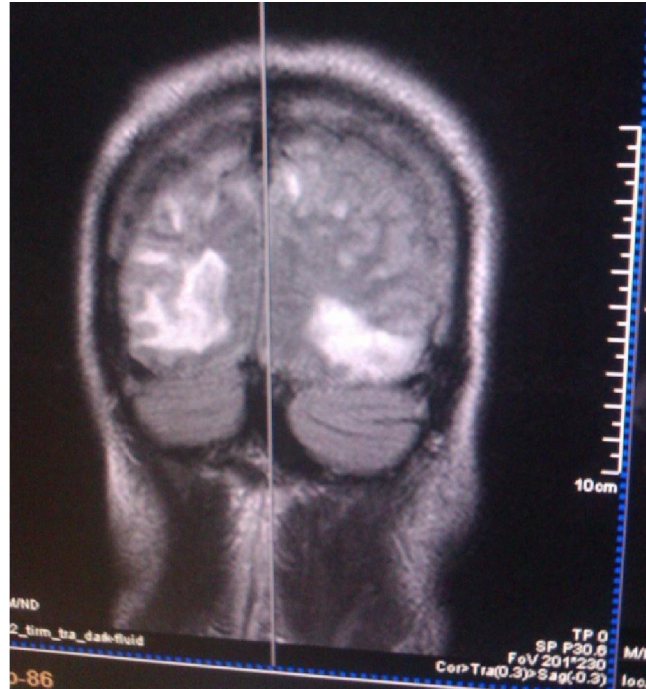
MRI Brain T2 FLAIR coronal showing bilateral parieto-occipital hyperintensities in a case of PRES
